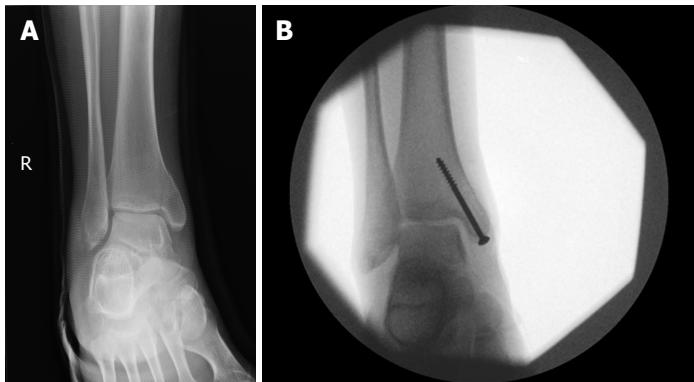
The management of an undisplaced completed medial malleolar stress fracture. A: Pre-operative antero-posterior radiograph; B: Intra-operative antero-posterior radiograph.
